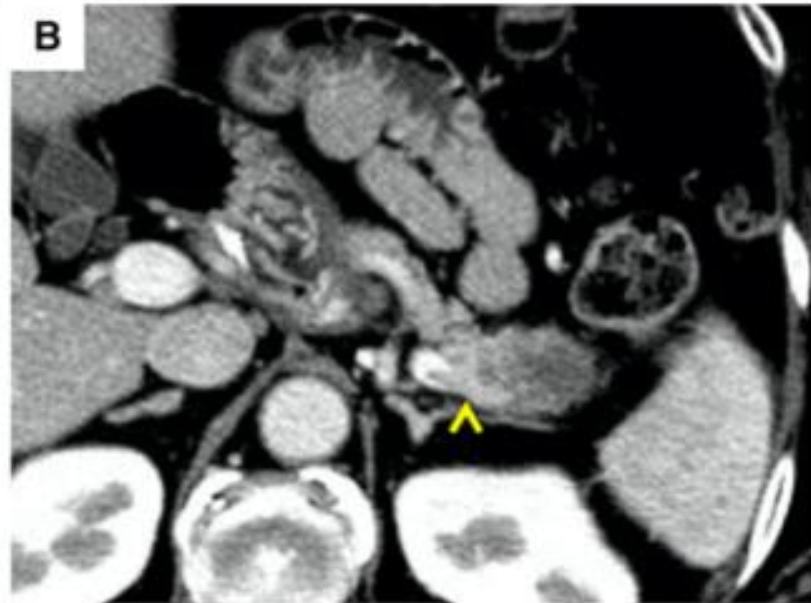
A, B ASqC in the pancreatic tail in a 56-year-old woman (case 2). Axial portal venous phase CT images show a lobulated lesion with an expansive central necrosis (*arrow*). The lesion has a tumor thrombus in the splenic vein leading to the lesion (*arrow-*
